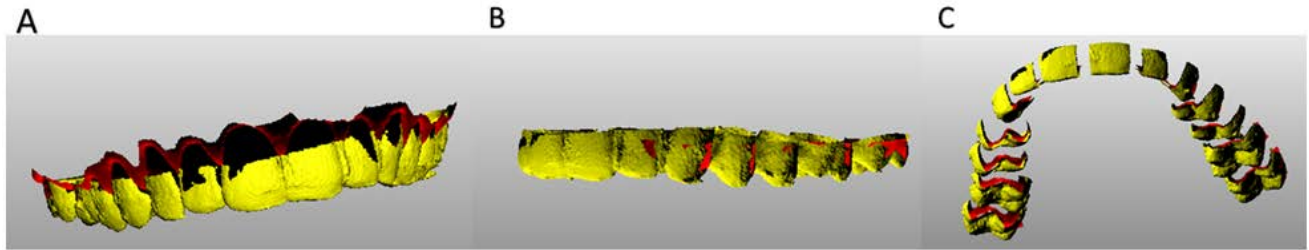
Example of the four different CBCT segmentation thresholds (Ez3DPlus software) : A – first threshold, B – second threshold, C – third threshold, D – fourth threshold.
